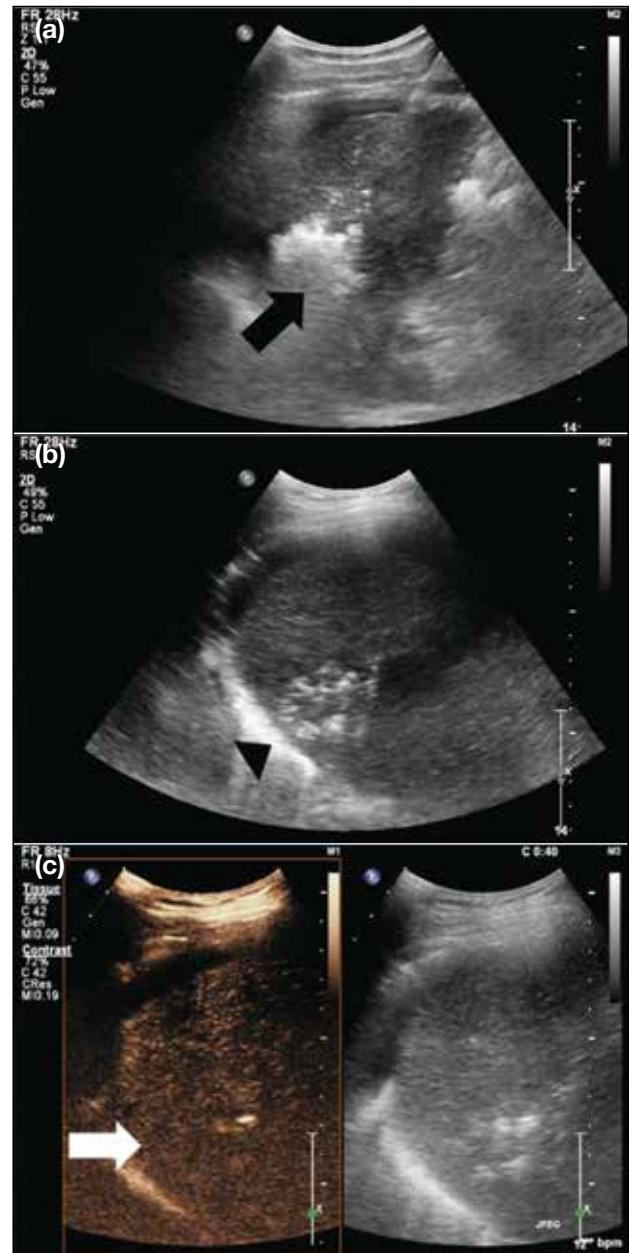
This patient had a hepatocellular carcinoma in segment VII of the liver. Percutaneous microwave ablation was performed. (a) Immediately after ablation, the ablation zone was largely obscured by a gas cloud (black arrow). (b) Twenty minutes after the ablation, the gas cloud had largely subsided and the ablation zone could be clearly demonstrated on ultrasound (black arrowhead). (c) Contrast-enhanced ultrasound performed with Sonazoid showed no marginal nodular enhancement adjacent to the ablation zone to suggest the presence of residual tumour (white arrow).
